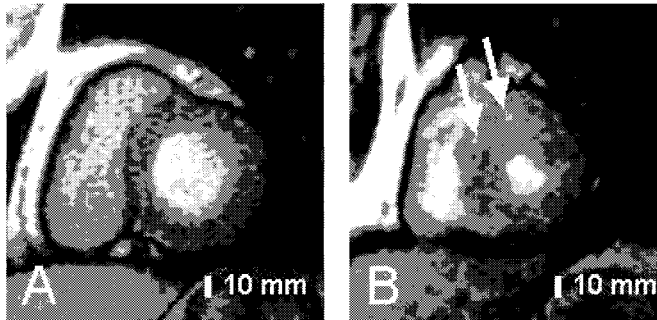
Contrast-enhanced T1-weighted inversion recovery images in a 52-year-old control subject (A), and in a 45-year-old male with HCM (B). Focal intramyocardial areas with a high signal indicative of fibrosis were found at the mid-ventricular level at the junction of the interventricular septum and the right ventricular free wall (arrows).
